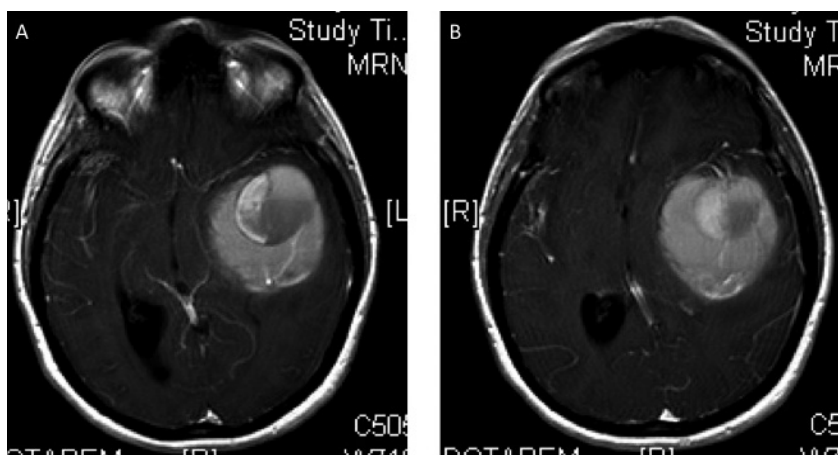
A, B) Pre-operative MRI with gadolinium that shows a disomogeneous enhancement of the tumor with solid and cystic components.
